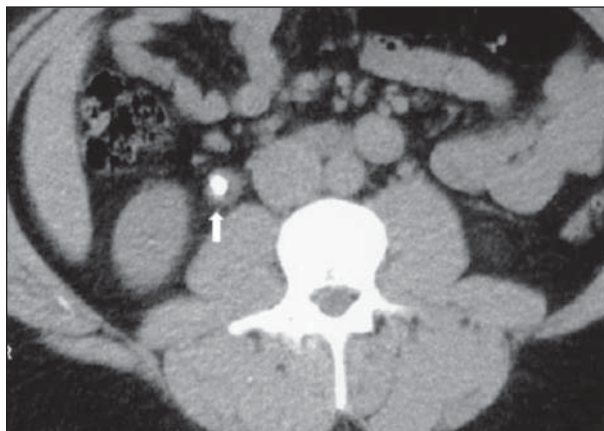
Ureteral wall edema. Non-contrast enhanced CT axial slices. A halo sign (arrow) involving this calculus on the middle ureteral third can be seen in this case.
